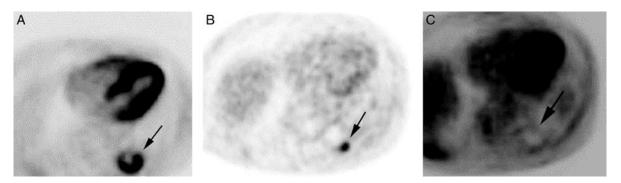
Suspicious PET findings following percutaneous ablation. A, Baseline axial attenuated corrected PET image preradiofrequency ablation for left-sided lung cancer shows an FDG-avid partially necrotic mass with SUV 10.9 (arrow). B, Axial attenuated corrected PET, 2 months after RFA, shows rim uptake but with focal uptake corresponding to the original tumor nodule (arrow), a pattern previously found to be suspicious for recurrence. C, Subsequent RFA of the mass was performed. PET image, 9 months after the salvage procedure, demonstrates rim uptake without focal uptake corresponding to the original tumor nodule, indicating response to treatment (arrow).
